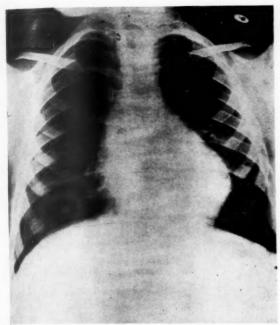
Radiograph of the heart after operation. Augmentation in volume (compare with Fig. 1).
